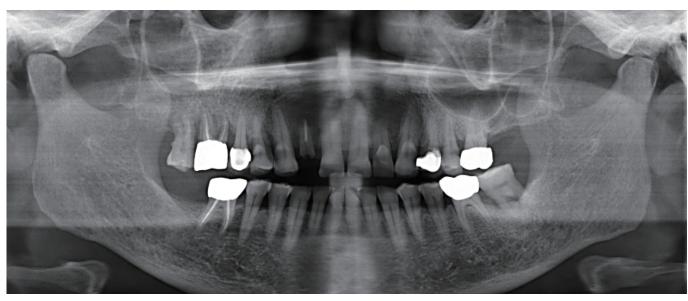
Pre-op panoramic x-ray.
